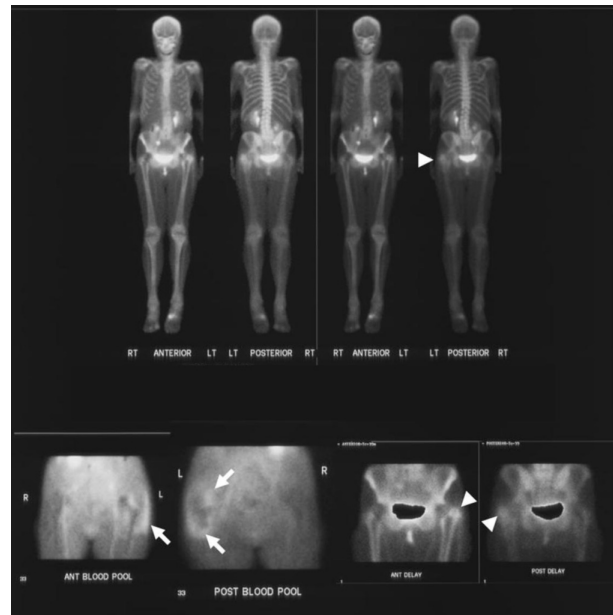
85-year-old female with metallosis of left total hip replacement. Anterior and posterior projections of a bone scintigraphy study using 30mCi IV technetium-99m-labeled methylene diphosphonate (Tc-MDP) in the 15-minute blood pooling and 3.0-hour delay phases were obtained. This scan demonstrates presence of bilateral THRs with significant increased uptake of Tc-MDP in the periprosthetic bony and soft tissues of the left hip joint in the blood pooling phase (arrows). Delayed phase scans also show mild Tc-MDP uptake in the left hip joint soft tissues (arrowheads). No abnormalities are visualized in the region of the right hip joint.
